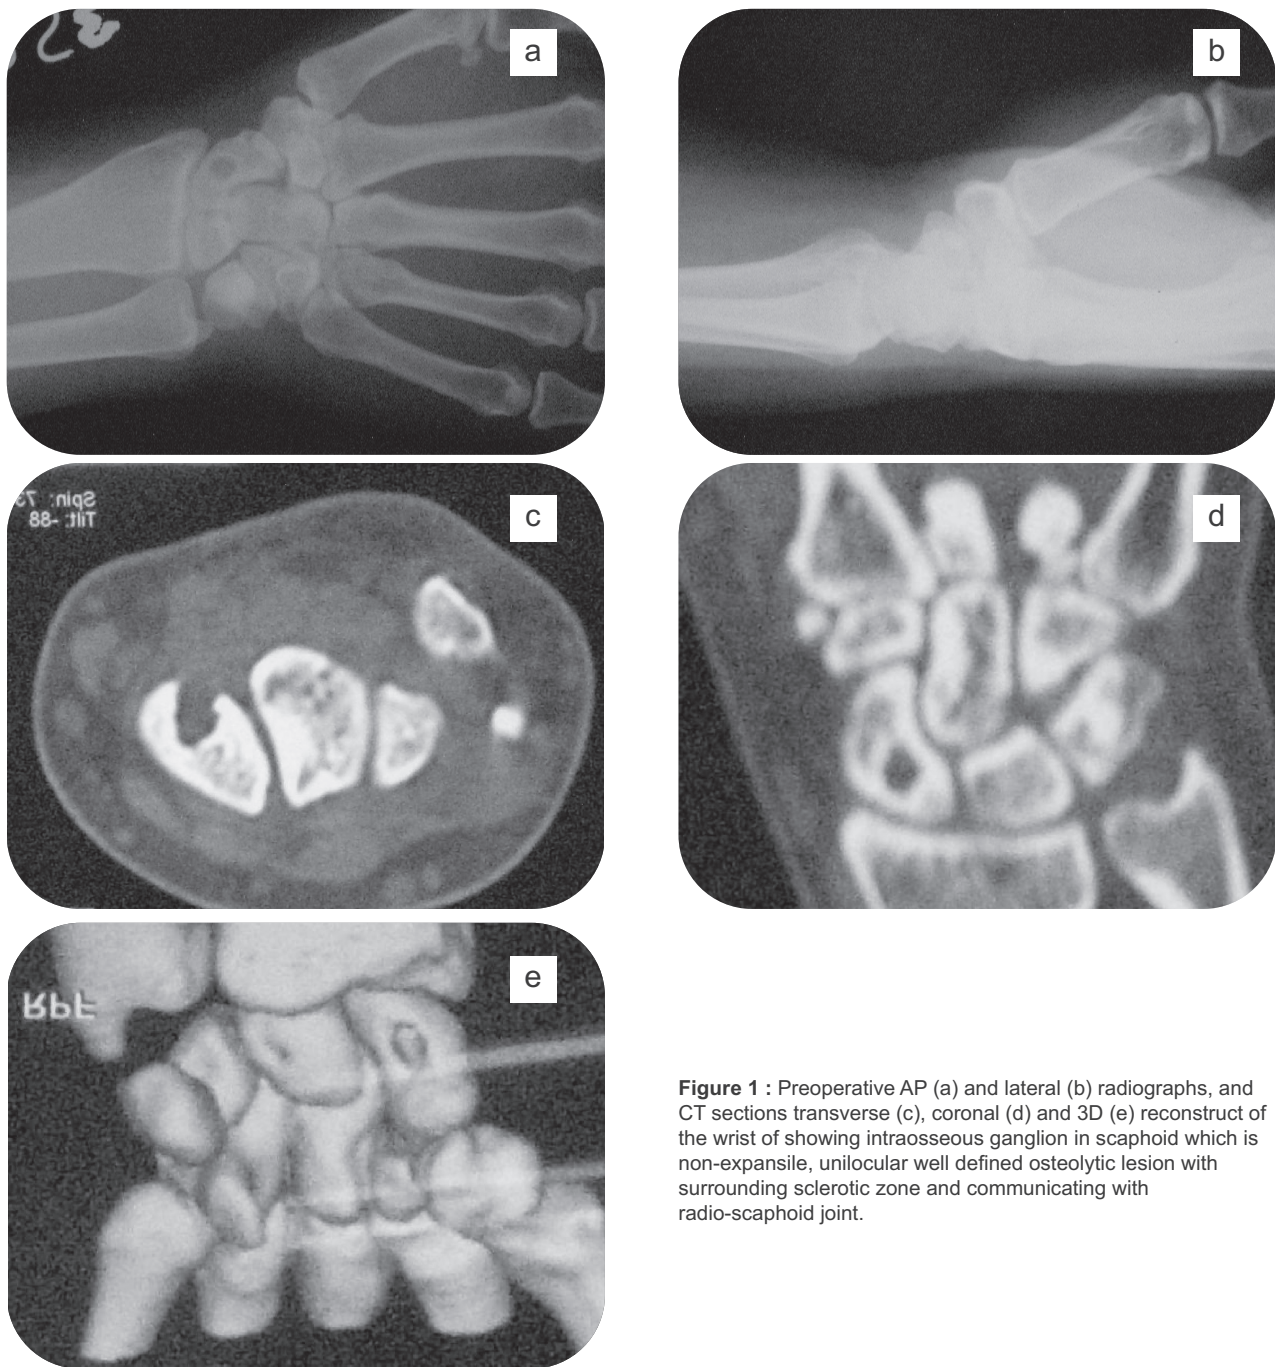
Preoperative AP (a) and lateral (b) radiographs, and CT sections transverse (c), coronal (d) and 3D (e) reconstruct of the wrist of showing intraosseous ganglion in scaphoid which is non-expansile, unilocular well defined osteolytic lesion with surrounding sclerotic zone and communicating with radio-scaphoid joint.
